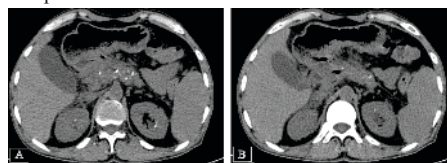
Non contrast CT abdomen shows (A) atrophic pancreas with multiple intraparenchymal calcifications and dilated main pancreatic duct; (B) few tiny foci of extraluminal air tracking to the lateral wall of pylorus.
